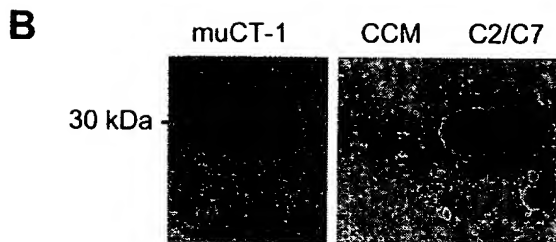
Muscle Cells Express mRNA for CT-1 and Secrete Mature CT-1 Protein
